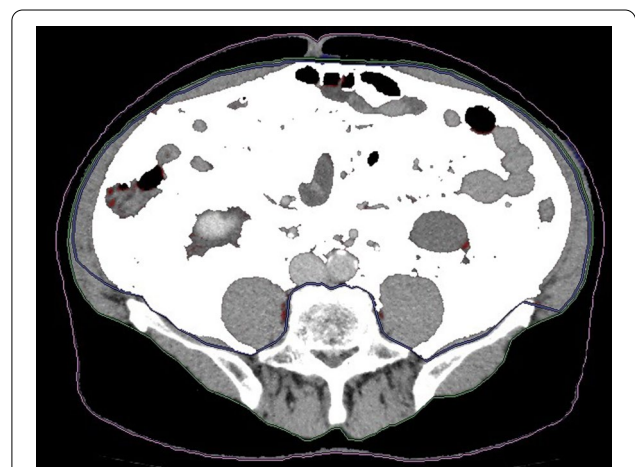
Computed tomography revealing the degree of fat distribution. The white area within the drawn circle is the visceral fat area
